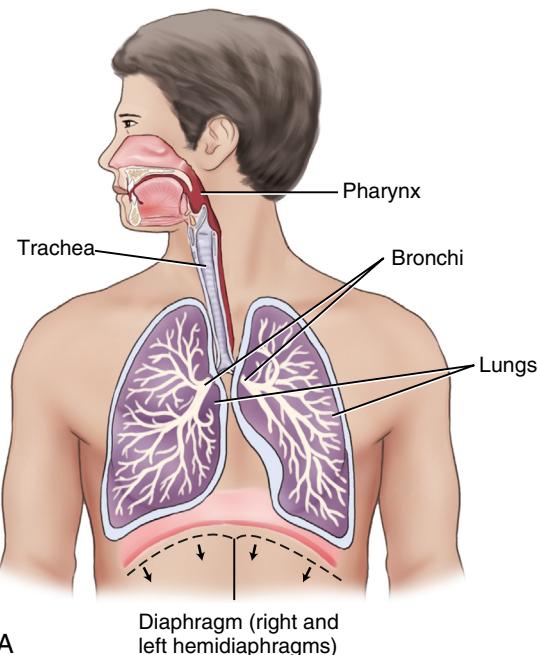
(A) The respiratory system. (B) The trachea and its bifurcation at the carina. (From Bontrager, K. L., & Lampignano, J. P. (2014). *Textbook of radiographic positioning and related anatomy* (8th ed.). Mosby.)
